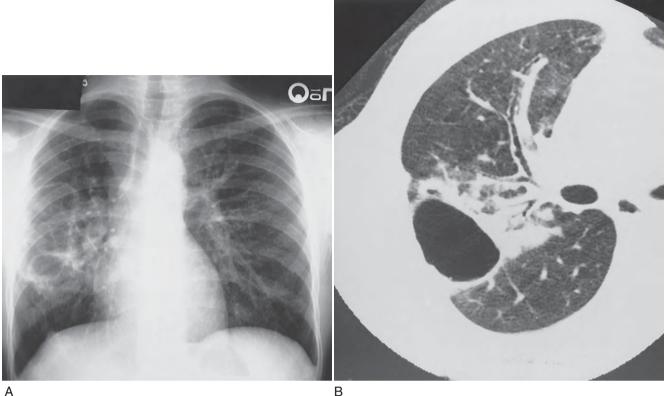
Churg-Strauss syndrome patient with a large cavitary lesion in the peripheral lung with adjacent pleural thickening and volume loss of the right lung (A). Chest CT scan demonstrating bronchiectasis of the right middle lobe in addition to the cavitary lesion (B).
